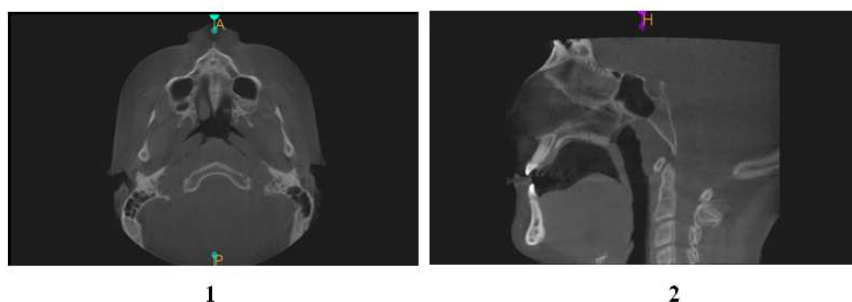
CBCT Images: 1-Axial View, Stage D is Visualized as 2 Scalloped, High-Density Lines at the Midline on the Maxillary Portion of the Palate The Midpalatal Suture cannot be Visualized in Palatine Bone. 2-Sagittal View
